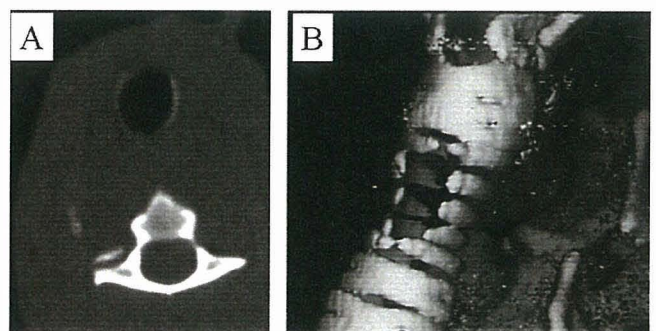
(A) Axial computed tomography image at operated site reveals fine luminal portrayal of reconstructed trachea. (B) Three-dimensional reconstructed image from fine axial sections shows no marked new cartilage formation.
